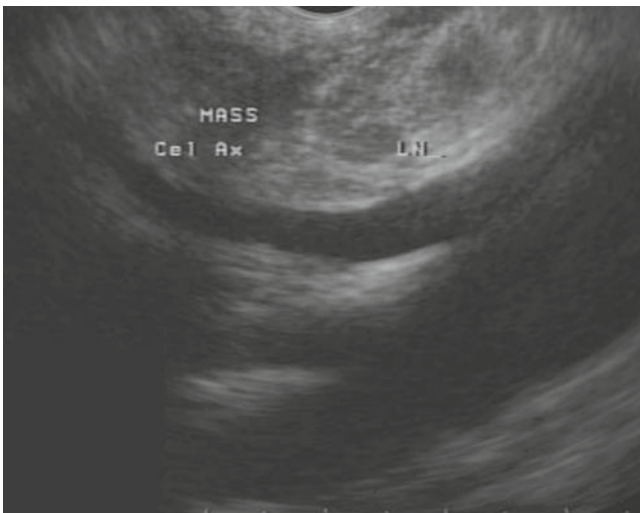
A 69-year-old man presents with mild abdominal pain, loss of appetite, and weight loss. Linear endoscopic ultrasound (EUS) image reveals a hypoechoic mass lesion in the body of pancreas encasing the celiac axis, consistent with periaxial adenocarcinoma. Diagnosis: Pancreatic mass (courtesy of Hazar Michael, MD. Robert Wood Johnson University Hospital)
